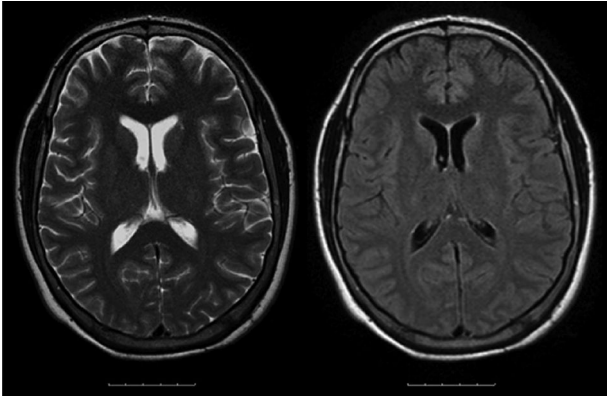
T2 (left) and FLAIR (right) imaging. Both are good at detecting altered water content in brain tissue. In the FLAIR image the free water in the CSF and ventricles is suppressed. © Anthony Pereira.
